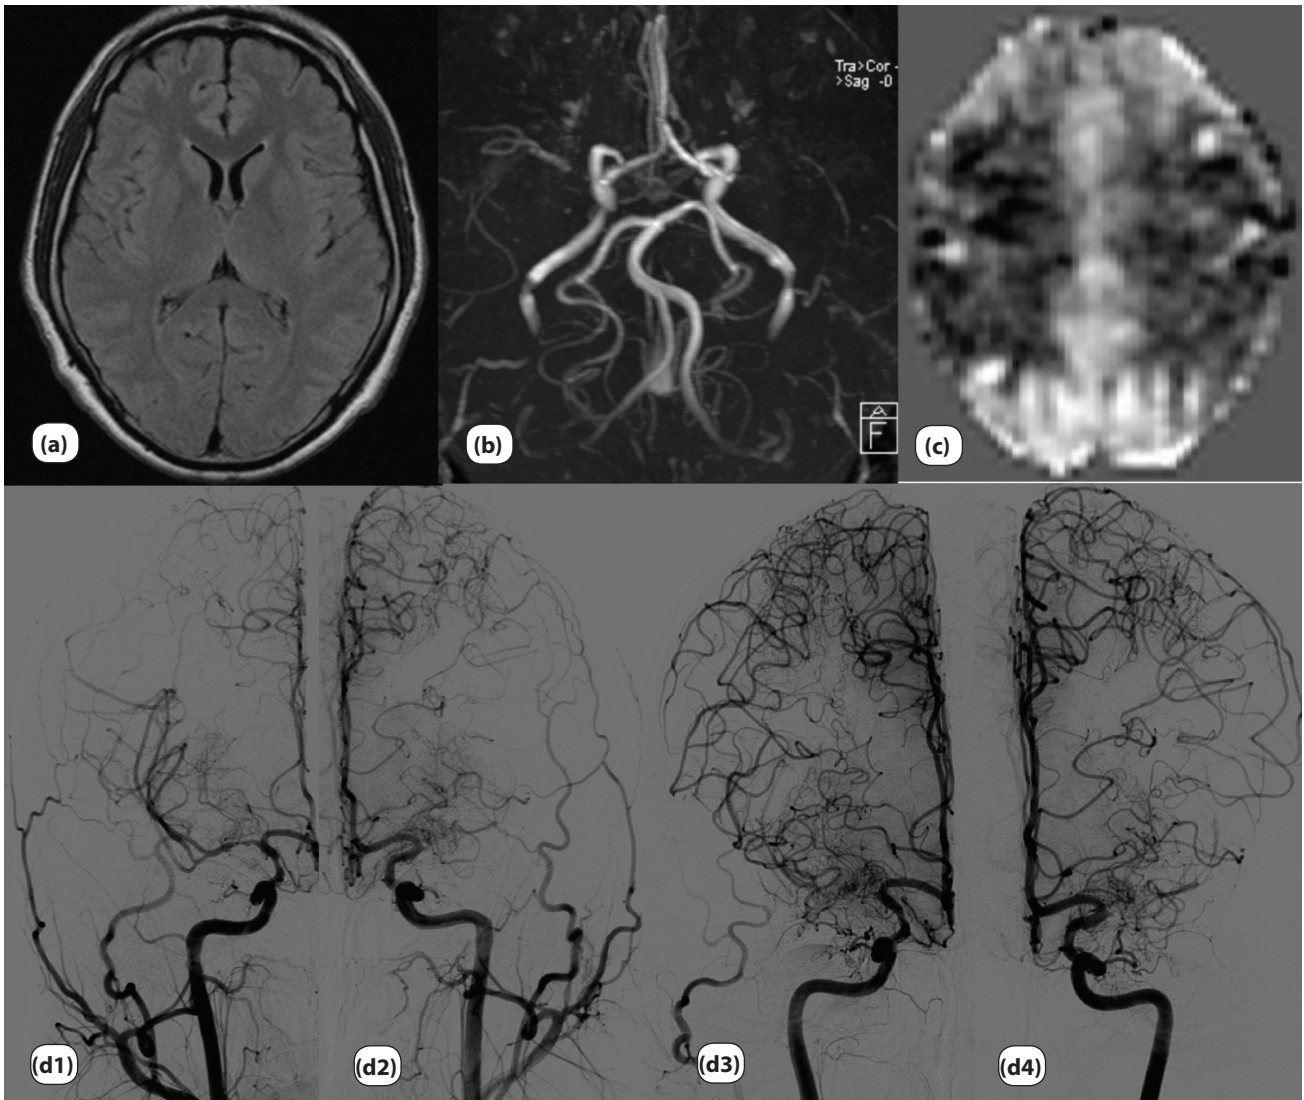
(a) Brain MRI with fluid attenuated inversion recovery (FLAIR) sequence: no parenchymal lesions; (b) Three-dimensional time-of-flight magnetic resonance angiography (MRA): absent flow signal in the left MCA and a severe stenosis in the proximal right MCA; (c) Pulsed arterial spin labeling (PASL): hypoperfusion in the distal part of both MCA territories; (d) Cerebral digital subtraction angiography (DSA): July 2012 – focal stenosis of 50% of the supraclinoid portion of the right ICA and irregular vessel wall with severe stenosis (65-70%) of proximal right MCA (d1), left MCA occlusion with collateralization due to pial branches of anterior cerebral artery (ACA) and external carotid artery branches (d2); One year later – proximal right (d3) and left MCA occlusions and left internal carotid artery (ICA) stenosis in the supraclinoid portion (d4) with exuberant collateralization.
